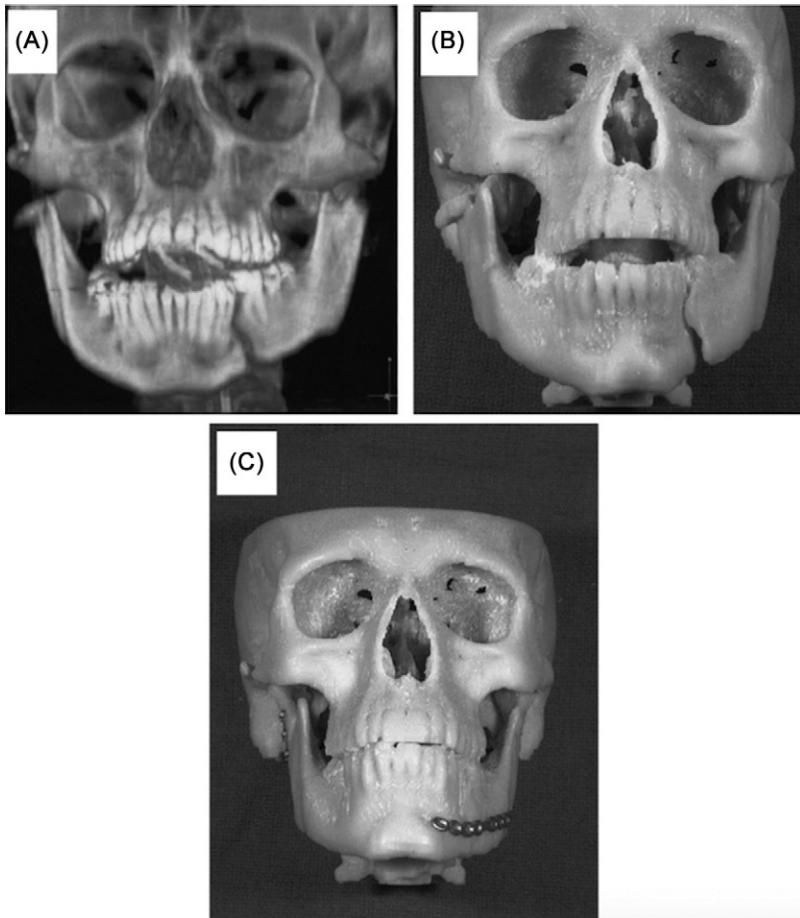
Creating 3D models of the maxillofacial fractures and repair. (A) CT image of bilateral subcondylar fractures and a left parasymphysal fracture; (B) 3D printed model of the same CT image; (C) 3D model of the repaired fractures using reconstruction plates.
